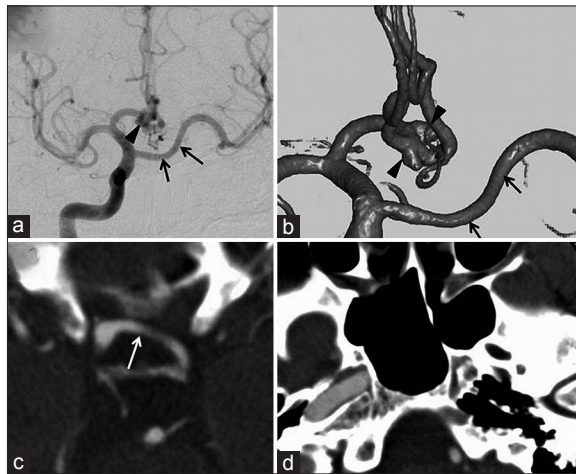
Right carotid angiogram (anteroposterior view) (a) three-dimensional digital subtraction angiogram. (b) Two anterior communicating artery aneurysms (arrowheads) of approximately 5-mm and 3-mm diameter, absence of the left internal carotid artery, and transcavernous anastomosis (arrows). Head enhanced computed tomography scan at the cavernous sinus. (c) Transcavernous anastomosis (arrow). Note that the left anterior cerebral artery is supplied via the anterior communicating artery. Head bone window axial computed tomography scan with contrast medium. (d) Absence of the petrous carotid canal on the left
